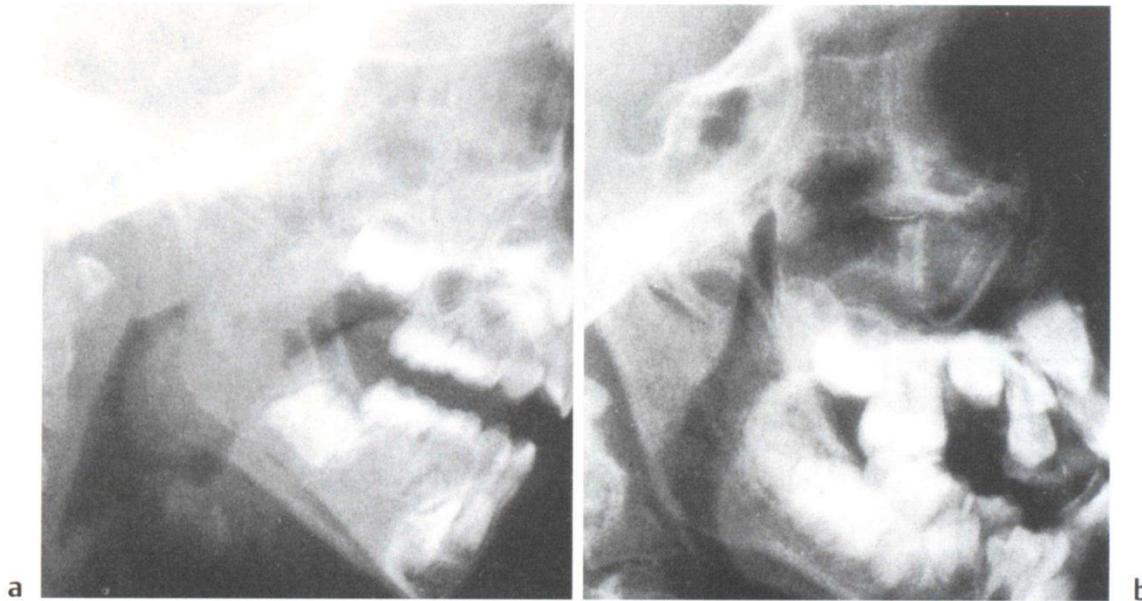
Accurate lateral radiographs are necessary. A wrongly angled radiograph (a) is not infrequently erroneously reported as showing “large adenoids.” It is not easy to maintain a child in the correct position; patience and skill are required by the radiographer. When checking the lateral radiograph for adenoids, therefore, it is essential to be sure that the lateral picture is true (b) before assessing the bulk of the adenoid lymphoid tissue.
